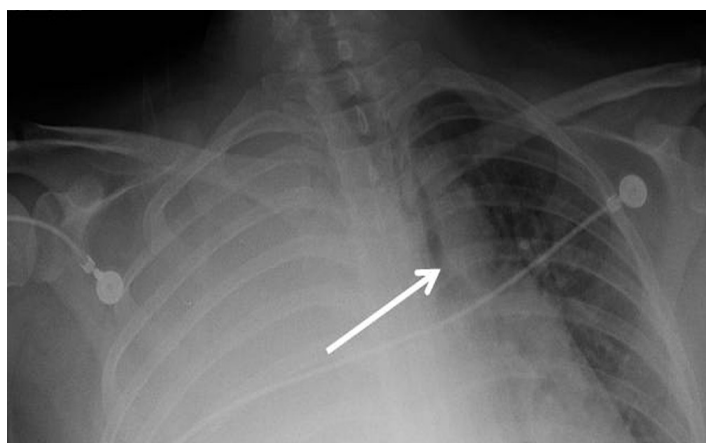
Portable chest radiograph reveals a right pyothorax with a mediastinum that is drastically shifted to the left.
